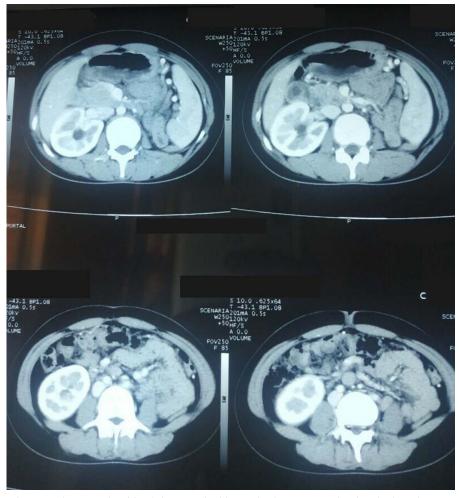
Contrast-enhanced computed tomography of the abdomen and pelvis reveals a heterogeneously enhancing hypodense mass lesion in the body of the pancreas and the absence of the left kidney.
